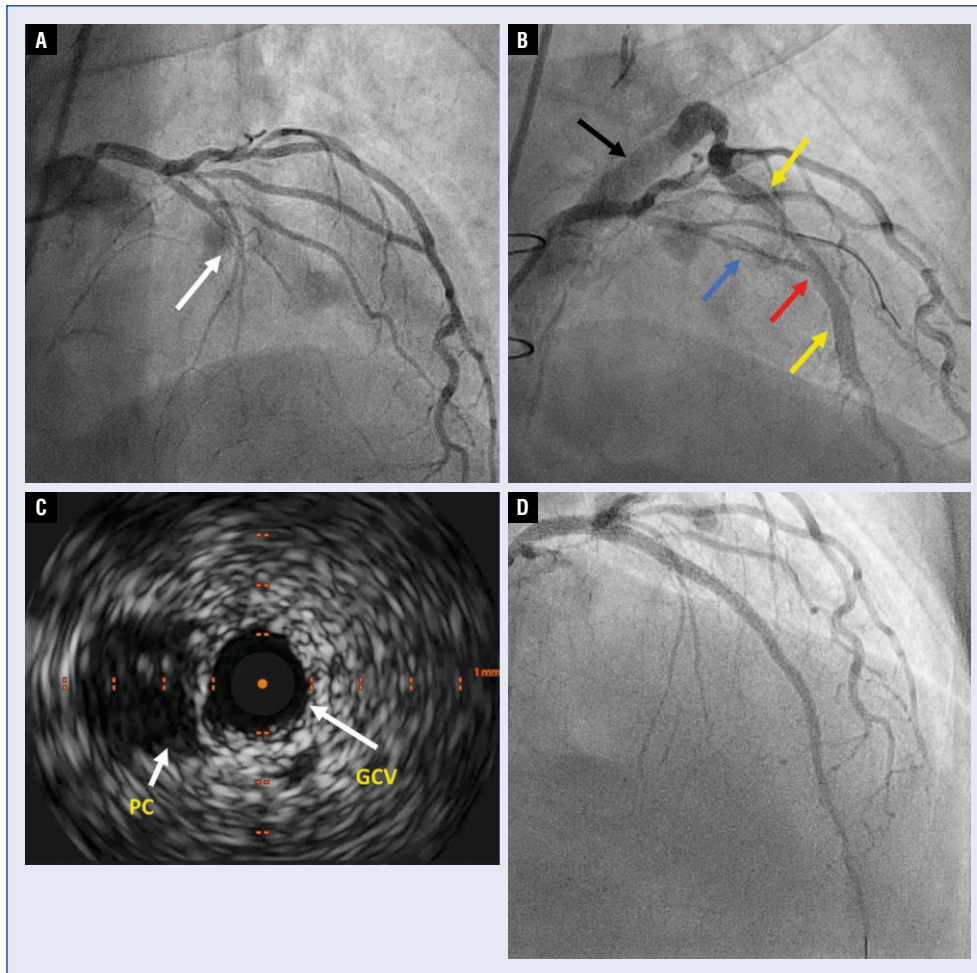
A. Left anterior descending (LAD) occlusion (white arrow); B. LAD to great cardiac vein (GCV) fistula; blue arrow — native LAD; red arrow — fistula; yellow arrows — GCV; black arrow — coronary sinus; C. Intravascular ultrasound identification of LAD proximal cap of occlusion with probe located in the GCV; PC — proximal cap; D. Final result of LAD percutaneous coronary intervention with complete sealing of the fistula.
